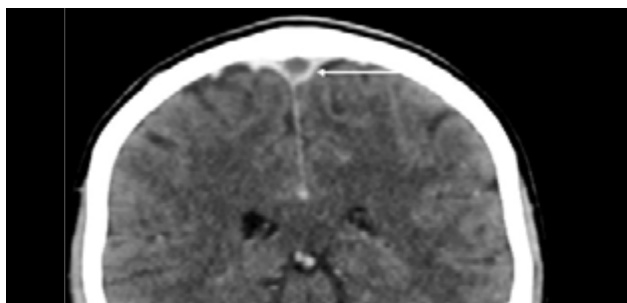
CT of a 41-year-old woman presenting with headache. Coronal imaging showing dural venous thrombosis of the superior sagittal sinus (arrow), demonstrating the empty delta sign.
